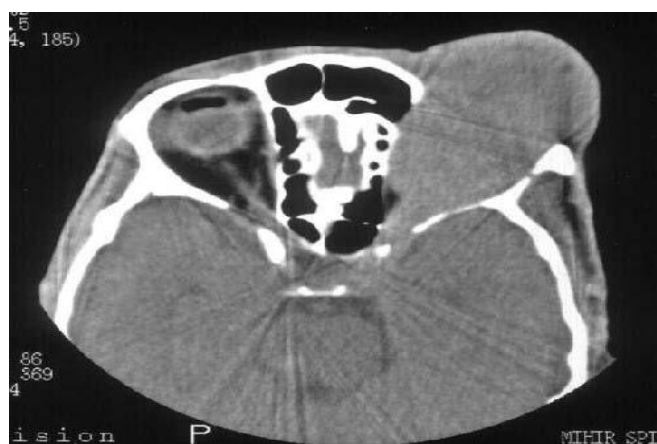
Plain CT of the orbit showed a hypodense mass involving the Extraocular muscles and Optic nerve with scalloping of the lateral and medial walls of the left orbit- Lymphoma
